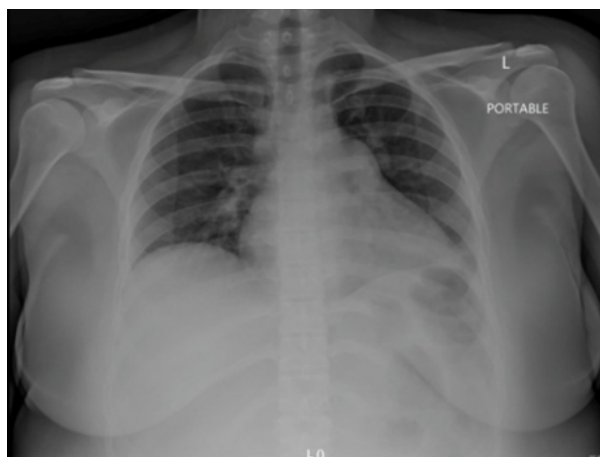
Chest X-ray showing cardiomegaly and clear lung fields
